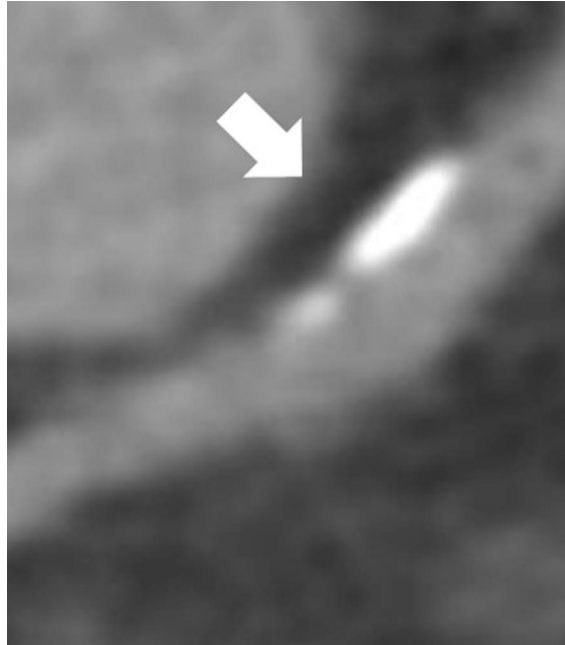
Noncontrast computed tomography detecting calcification. Calcification appears as white in the noncontrast CT image.
